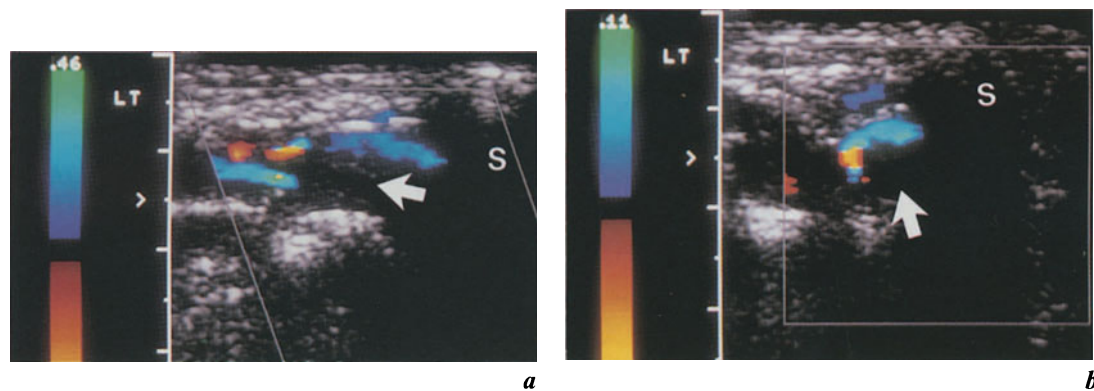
a. Longitudinal section of the left subclavian vein in a 25 year old female patient with pulmonary embolism confirmed by scintigraphy: the medial aspect of the subclavian vein in this case could only be demonstrated from a supraclavicular approach (S=shadowing caused by the clavicle). The arrow indicates an area devoid of color display of blood flow corresponding to an area of thrombus along the vessel wall; thrombosis of the vein is not complete, however
